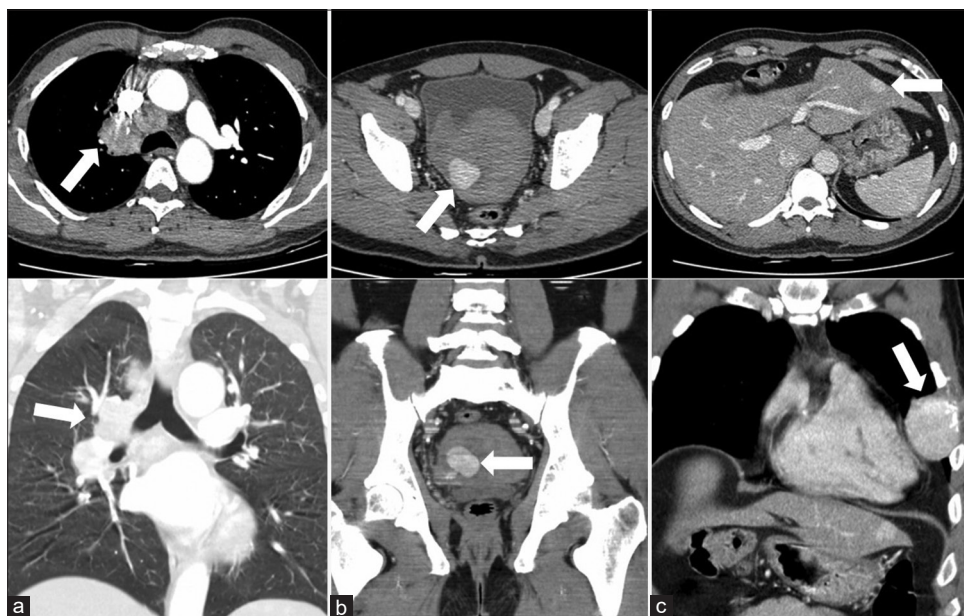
(a) Contrast enhanced computed tomography of thoracic region showing a heterogeneously enhancing soft tissue lesion with irregular margin (size 3.8 cm × 3.7 cm) in the hilar region of right lung with partial encasement and indentation of the right main bronchus and bronchus intermedius (white colour arrow). (b) Contrast enhanced computed tomography of pelvic region showing 3.0 cm × 2.2 cm sized soft tissue lesion along the right lateral wall of urinary bladder (white colour arrow). (c) Contrast enhanced computed tomography of thoracoabdominal region showing a well-defined enhancing lesion of size 2.5 cm × 2.2 cm in the segment III of liver (white colour arrow in transaxial image) and enhancing soft tissue lesion of size 5.0 cm × 5.0 cm involving and destroying left sided 5th rib (white colour arrow in the coronal view in the lower row)
